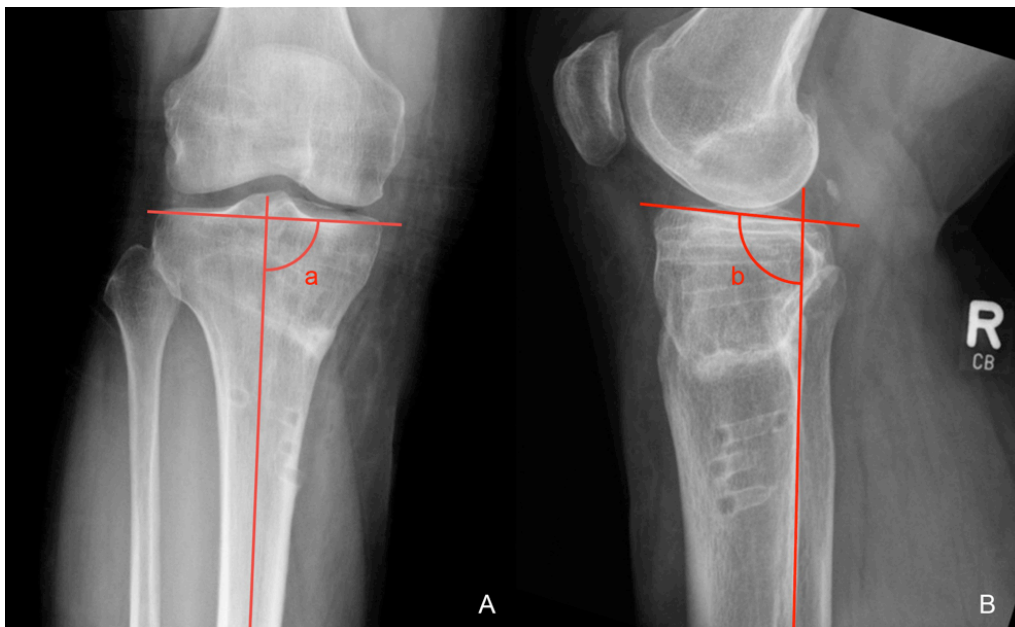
On the left side (A) AP radiograph two days after removal of the implant showing the method for measurements of the medial proximal tibial angle (angle a, MPTA). On the right side (B) lateral radiograph two days after removal of the implant demonstrating the method for measurements of the tibial slope (angle b).
